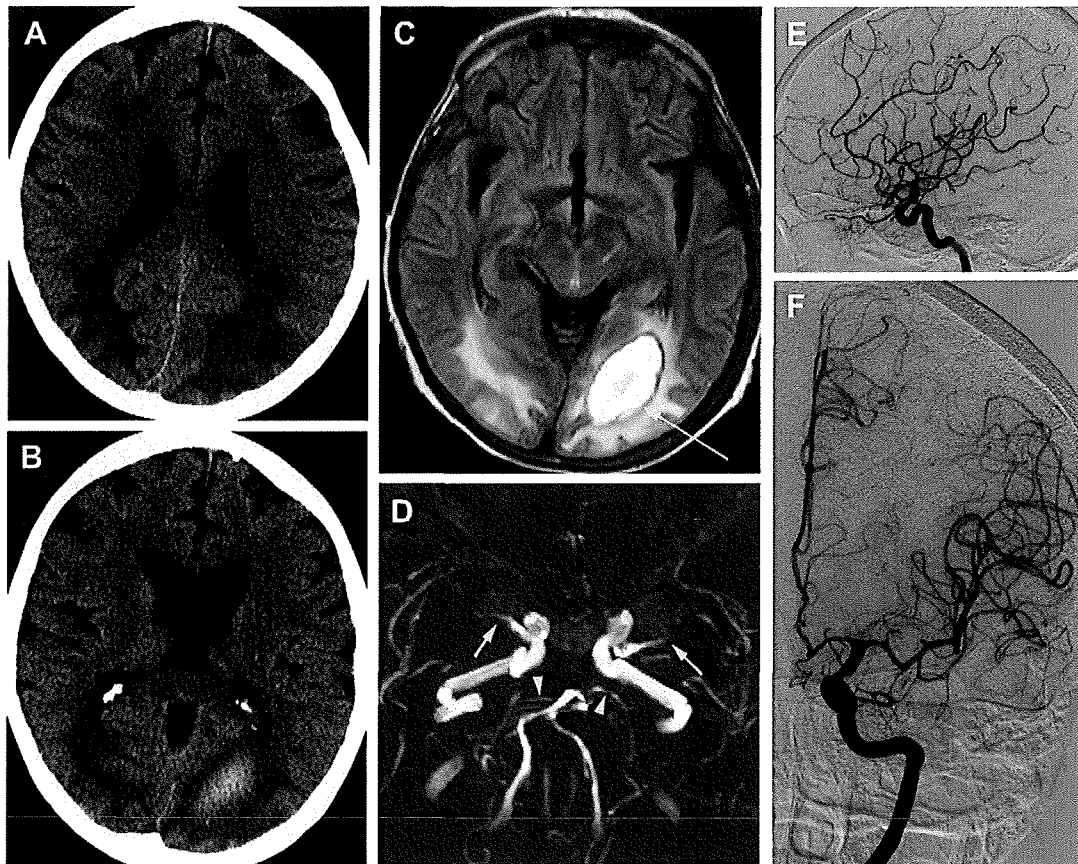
A 56-year-old woman with septic shock, renal failure, and thrombocytopenia developed mental status changes. Axial noncontrast CT images (A, B) demonstrate confluent cortical/subcortical hypoattenuation involving more of the parietal and occipital lobes than the frontal lobes, in a pattern consistent with PRES. Intraparenchymal hemorrhage in the left occipital lobe is also present. Axial FLAIR MR image (C) demonstrates confluent cortical/subcortical FLAIR hyperintensity in the occipital lobes as well as the intraparenchymal hemorrhage in the left occipital lobe (arrow). Collapsed 3-dimensional time-of-flight MR angiographic image (D) demonstrates spasm with cutoff of the middle cerebral arteries bilaterally (arrows) as well as irregularity of the posterior cerebral arteries bilaterally (arrowheads) consistent with the vasculopathy of PRES. Follow-up catheter angiograms (E, F) display a normal left middle cerebral artery, consistent with resolution of the vasculopathy of PRES.
